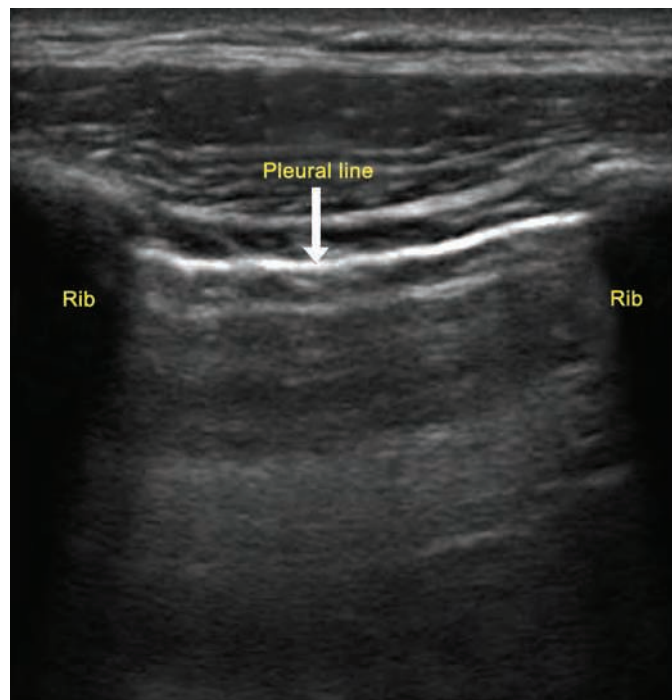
Lung sliding sign: It is a dynamic sign seen on ultrasound in normal aerated lung corresponding to the to-and-fro movement of the visceral pleura on the parietal pleura and can be identified on ultrasound as horizontal movement along the pleural line
